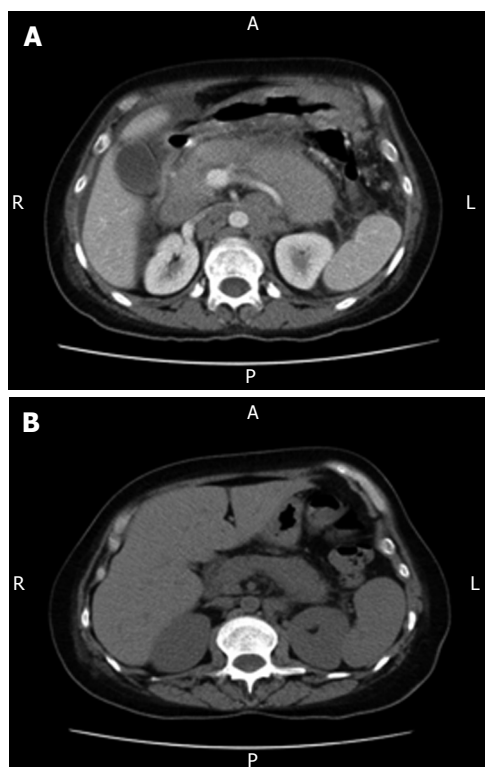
A: Baseline CT scan (pre-therapy). Abdominal CT scan shows diffusely enlarged pancreas due to infiltrative neoplasm, along with bulky retroperitoneal lymphadenopathy, bulky peripancreatic, mesenteric adenopathy, ascites and peritoneal carcinomatosis; B: Post-therapy CT Scan (non-enhanced). A follow-up CT scan of the abdomen reveals a marked decrease in size of the pancreas and retroperitoneal lymph nodes.
